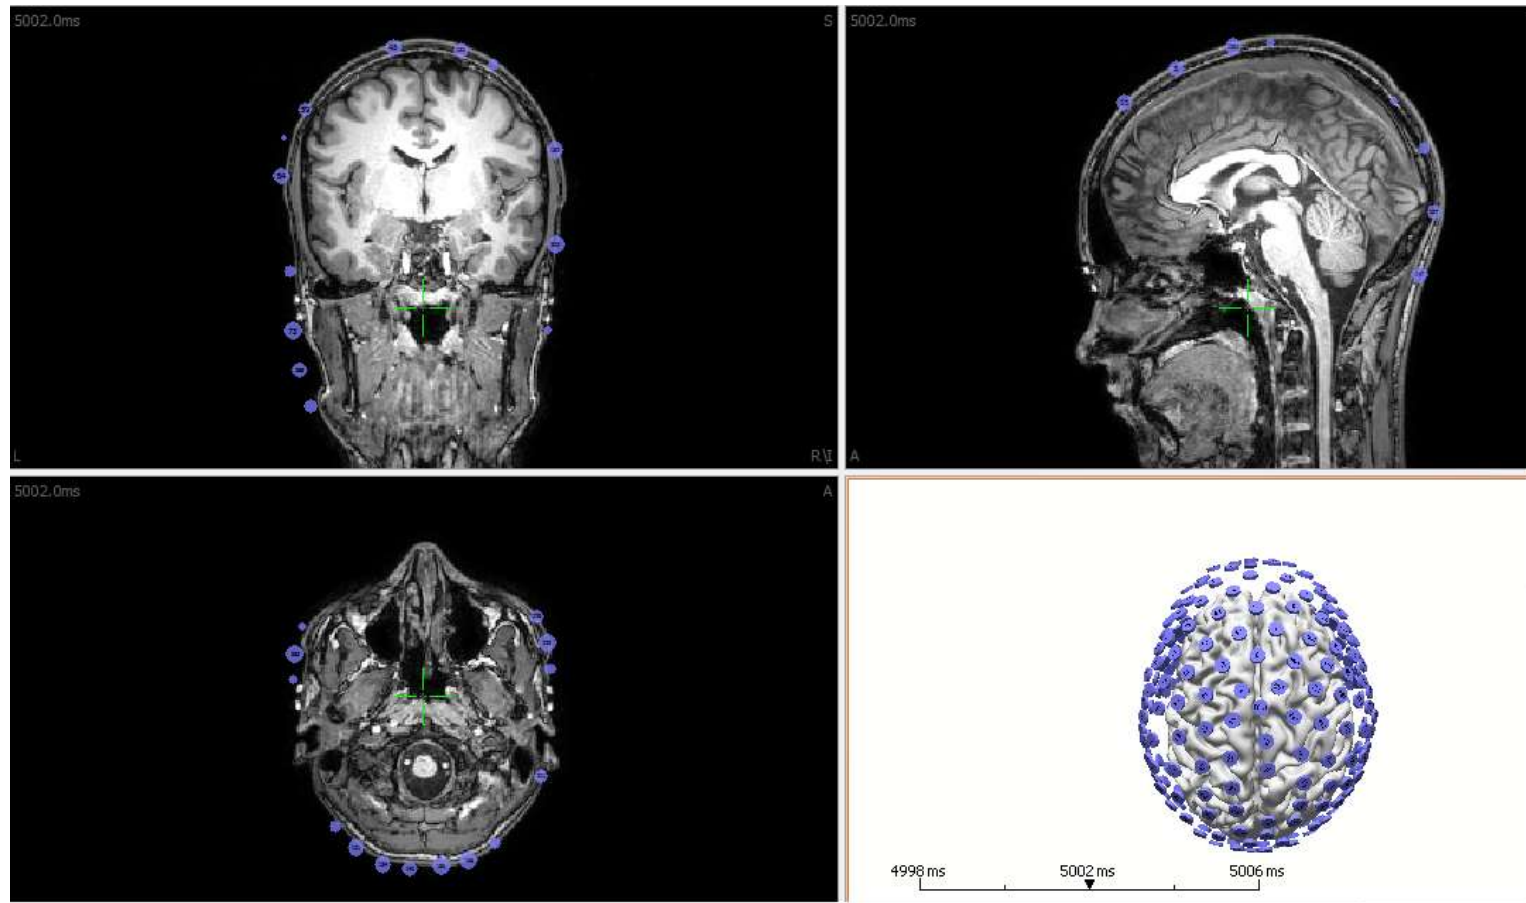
dEEG array fused to MRI scan and relationship to segmented cortical brain
